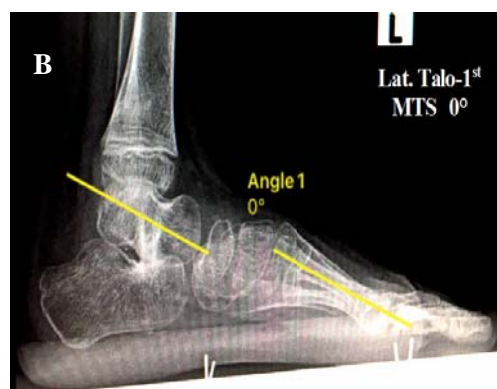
Radiographs showing measurement of preop. (A) and postop. (B) lat. talo-1st MTS angles.
